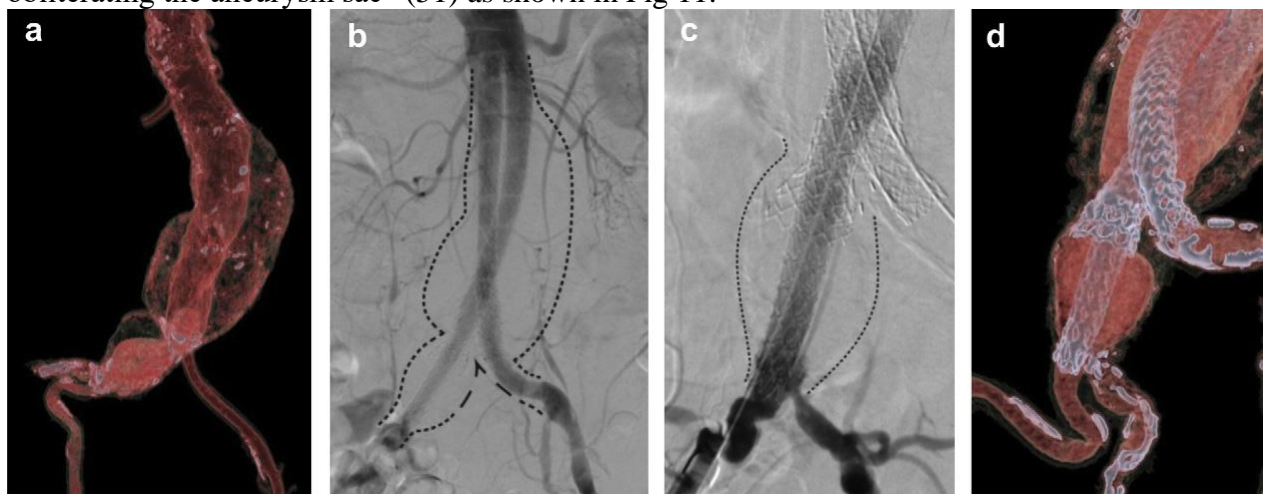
“Treatment of 6.3 cm AAA with short, funnel neck and 3.7 cm right CIAA. (a) Pre-op 3D-CT reconstruction and (b) Post-op angiogram. (c) Post-op angiogram showing exclusion of the iliac aneurysm with preservation of IIA flow and (d) 3D-CT reconstruction of the CIAA after treatment with complete exclusion of the aortic and iliac aneurysms.” Figure and explanation taken from Krievins et al. (109)
